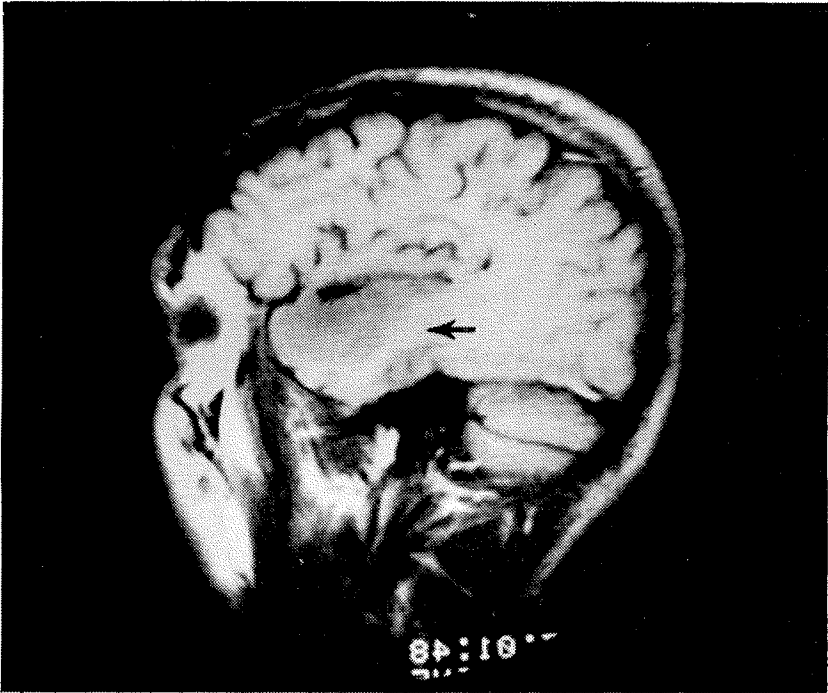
Temporal Lobe Glioma. Sagittal MR image shows low intensity area involving superior temporal gyrus and anterior temporal lobe.
